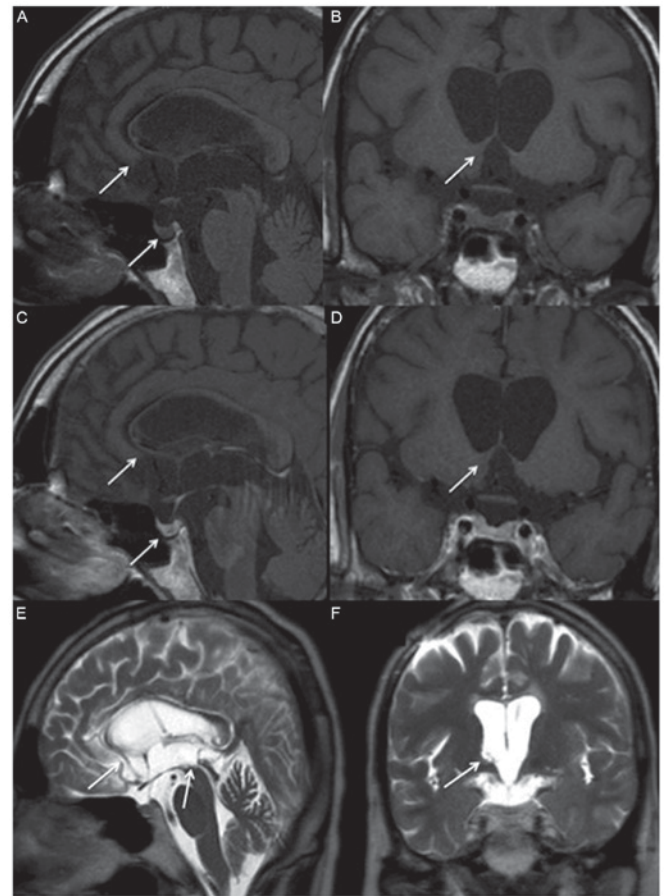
Magnetic resonance imaging of suprasella two years following treatment. The tumors over the basal ganglion, hypothalamus, corpus callosum, posterior hippocampus, pineal gland, stalk and posterior pituitary gland have disappeared, as indicated by arrows, in (A) non-contrast sagittal, (B) coronal, (C) contrast sagittal and (D) coronal T1 weighted images, as well as (E) T2 weighted sagittal and (F) coronal images.
